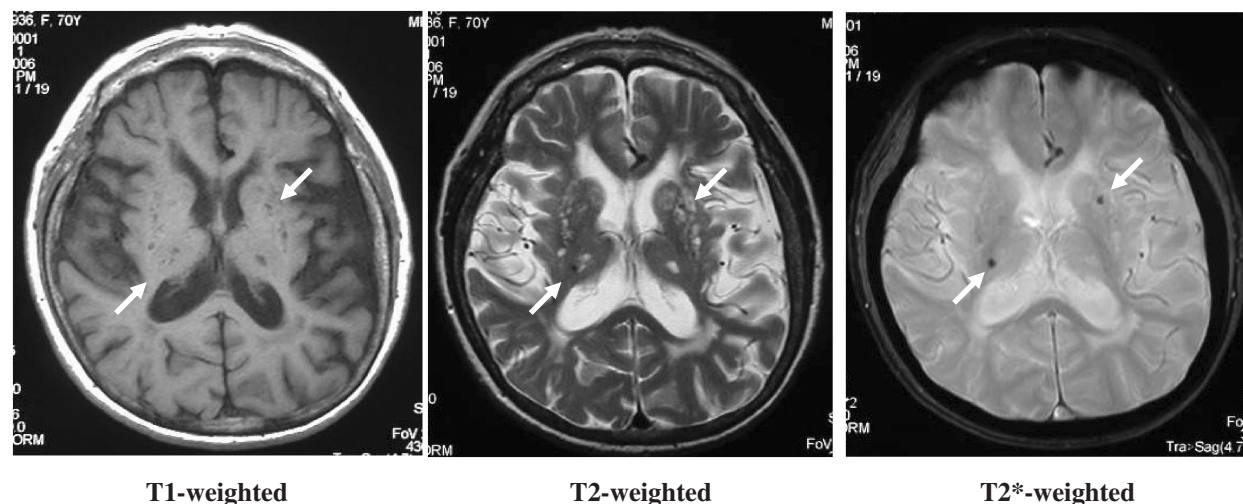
Cerebral microbleeds (CMBs) examined by MRI, including T1, T2 and T2*-weighted MRI images in which T2*-weighted MRI clearly demonstrates the presence of CMBs (arrows), although T1 or T2 MRI can barely demonstrate its presence (70-year-old woman with CMBs).
